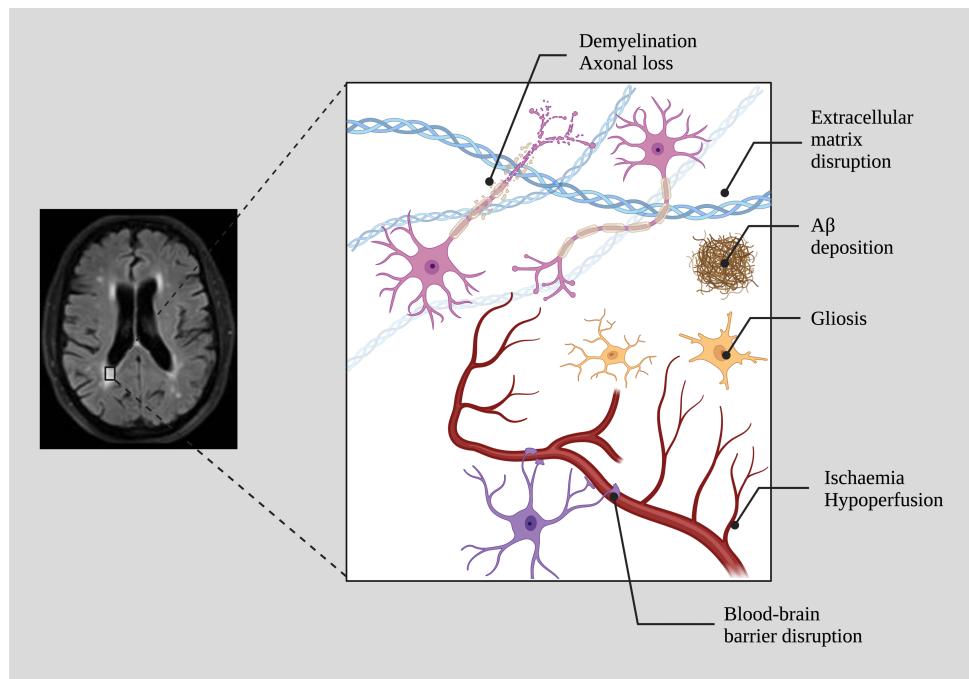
Pathological changes that may contribute to the manifestation of white matter hyperintensities (WMHs). Depending on the region and disease context, a mixture of these changes may contribute to the appearance of WMHs on MRI. A_β, beta-amyloid. T2-FLAIR image reproduced from Griffanti et al. [23]. Created with BioRender.com.
